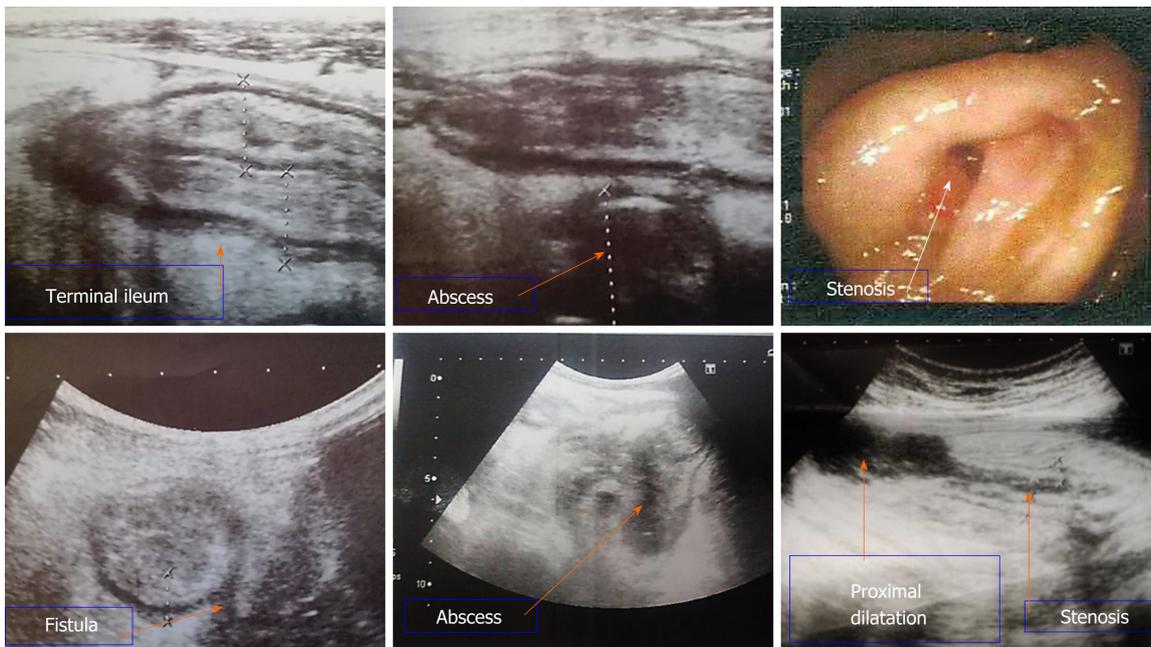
Bowel ultrasound and colonoscopy images. Bowel ultrasound demonstrates diffuse terminal ileal wall thickening likely of inflammatory nature with sonographic evidence of fistulization with mesenteric abscess formation. Stenosis which was detected during colonoscopy was seen by bowel ultrasound with proximal dilatation.
